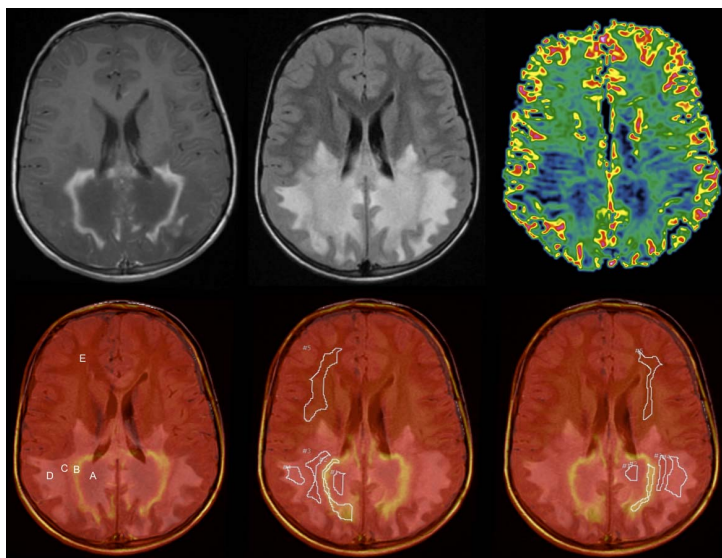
Nine-year-old male patient with symptomatic ALD. Post-contrast axial T1-weighted, FLAIR, nCBV map and fusion images (with regions of interest) are shown. Five different zones of involvement are noted in the white matter, with nCBV values markedly decreased within zone A, preserved to mildly increased values in zone B-C, slightly decreased in zone D and normal values in zone E.
